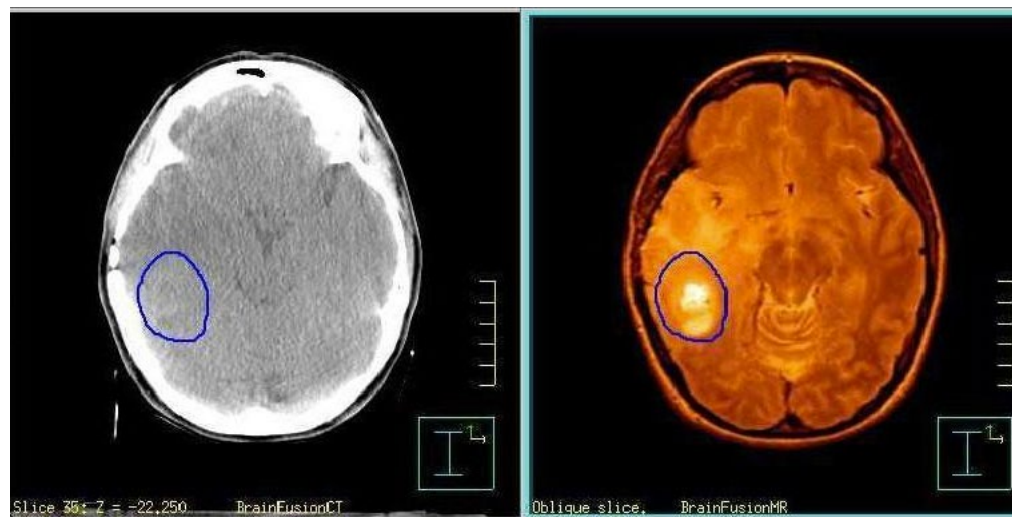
Image right. CT, MRI image fusion[1]
